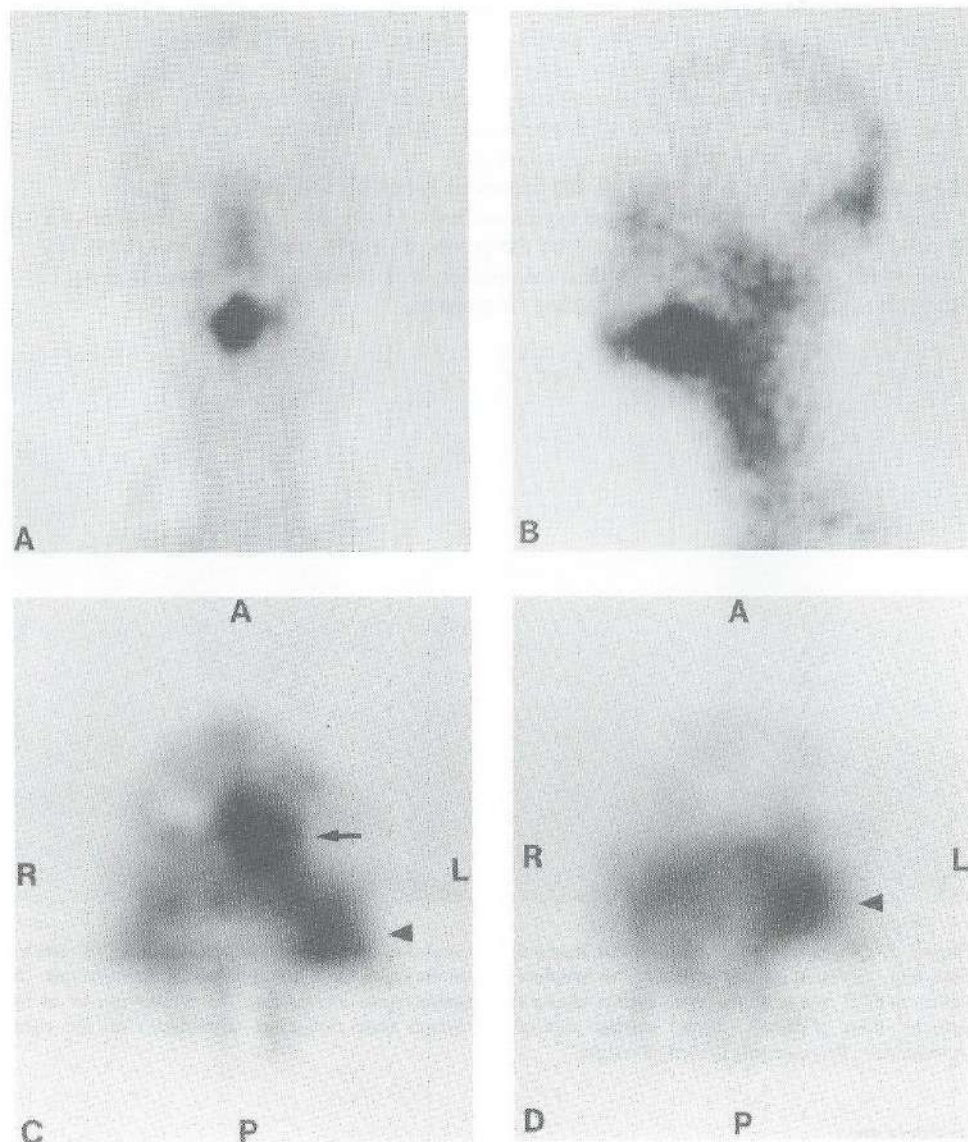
Patient 23. (A) Planar anterior image of the head and neck 21 h after injection of  $^{99m}\text{Tc}$ -labeled E48 IgG. Note the high activity in the primary tumor of the tongue. On this image the lymph node metastases in the left subdigastic and midjugular levels of the head and neck are not visualized. (B) The left lateral image shows the primary tumor in the tongue. The lymph node metastases are not visualized. (C) Axial SPECT images show the primary tumor (arrow) as well as the subdigastic lymph node metastasis (arrowhead) in one axial plane and separately (D), the midjugular lymph node metastasis (arrowhead) in a lower axial plane. A=anterior; P=posterior; R=right; L=left.
